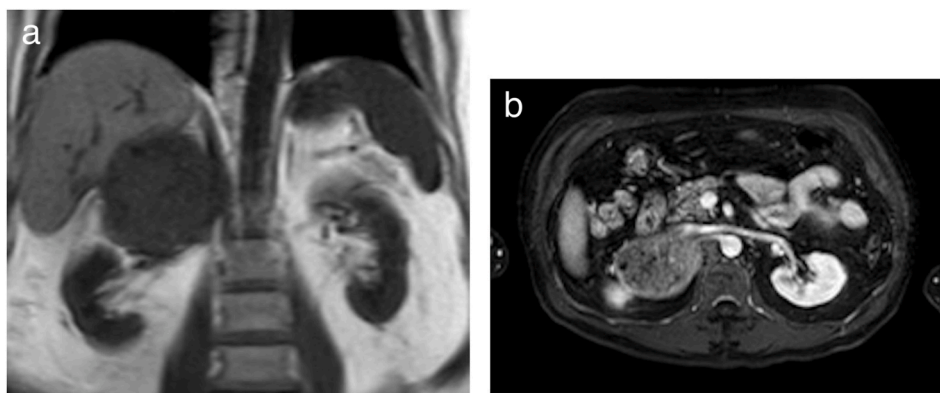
Pre-operative MRI revealing (a) right adrenal mass (b) IVC thrombus.
